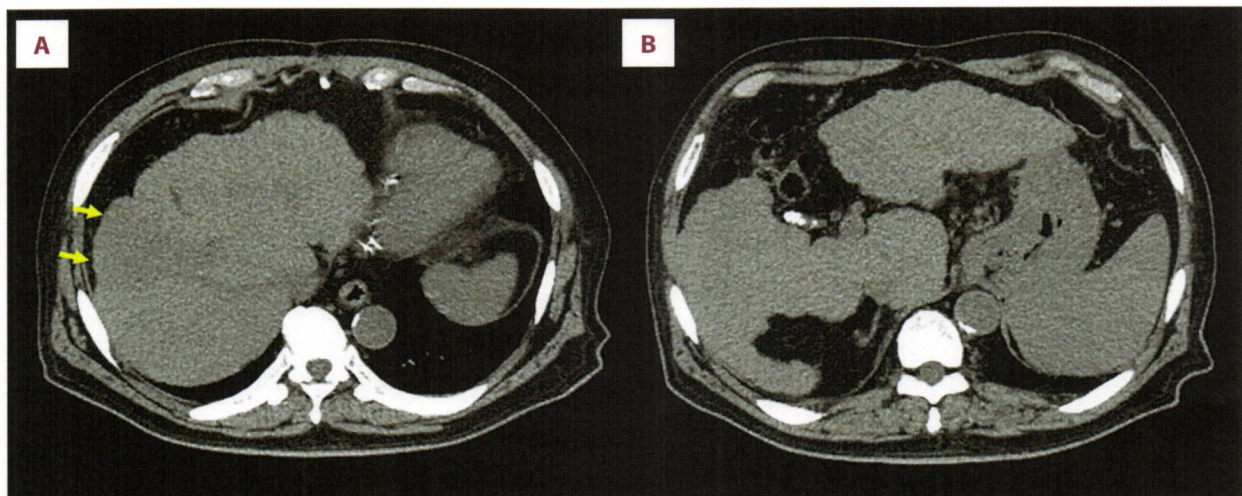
Abdominal plain CT findings at the initial diagnosis. A hepatic mass was incidentally detected in the cirrhotic liver (A, yellow arrows). Additional findings included a cirrhotic liver, developed collateral vessels, a congested stomach, and splenomegaly (A, B). CT – computed tomography.
